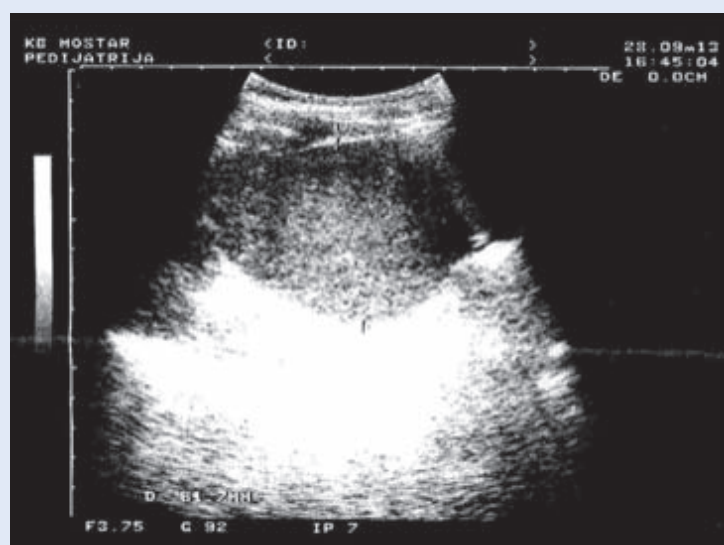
Ultrasound scan of Wilms tumor in left kidney
